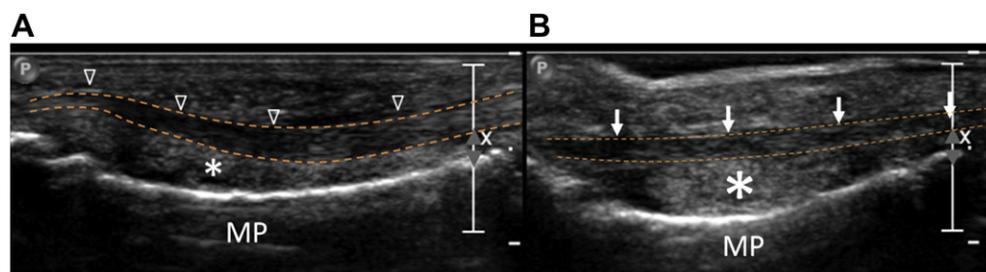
Sonographic appearance of “climber’s finger” shows (B) straightened flexor tendon (arrows) compared to (A) normal curved shape (open arrowheads). The margin of tendons is marked with broken lines. Note that gaps (*) between flexor tendon and volar surface of metacarpal bone (MP) is increased in (B).
